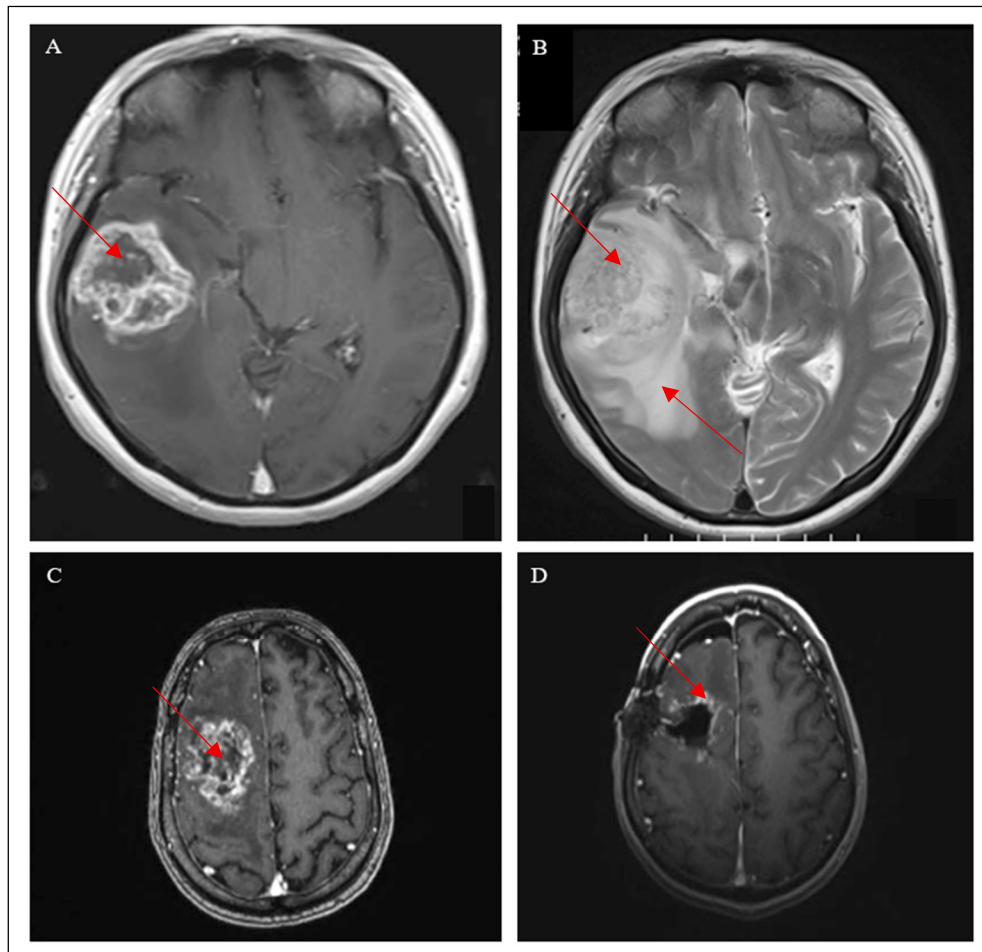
MRI Sequences of GBM. (A) contrast T1-weighted image showing necrotic core of the tumour; (B) T2-weighted image showing highly infiltrative tumour with peritumoral oedema; (C) Preoperative contrast T1-weighted image showing frontoparietal tumour mass with necrotic area; (D) Intraoperative contrast T1-weighted image with residual tumour tissue at the resection cavity. Adapted from Ideguchi et al. (2015). and G. Kuzmik et al. (2017) [ref 61: 62]
